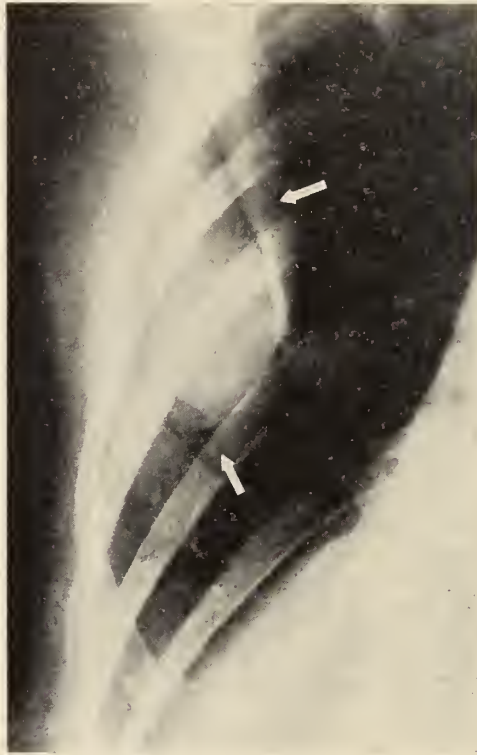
Antero-posterior roentgenogram showing the tumor before operation
